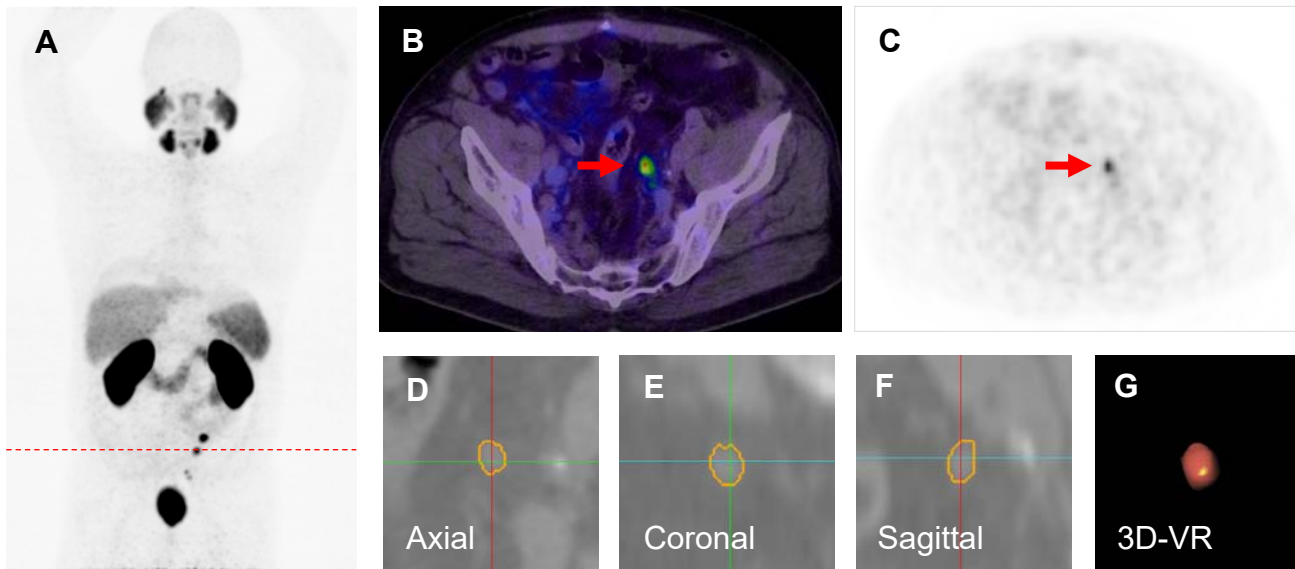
A 58-year-old patient with PSA relapse of 4.9 ng/mL, 9 months after prostatectomy (Gleason score 6, initial PSA 10 ng/mL). Patient presented multiple ^{68}Ga -PSMA-PET-positive nodes as shown in the PET maximum intensity projection (a). A positive node (red arrow) with PSMA uptake SUVmax 7.2 (b,c) was segmented using Fraunhofer MEVIS software. Short-axis diameter 5.93 mm, long-axis diameter 7.73 mm and volume 0.31 ml. Image (d, e, f) show the segmented lymph node on each plane and (g) the volume rendering.
